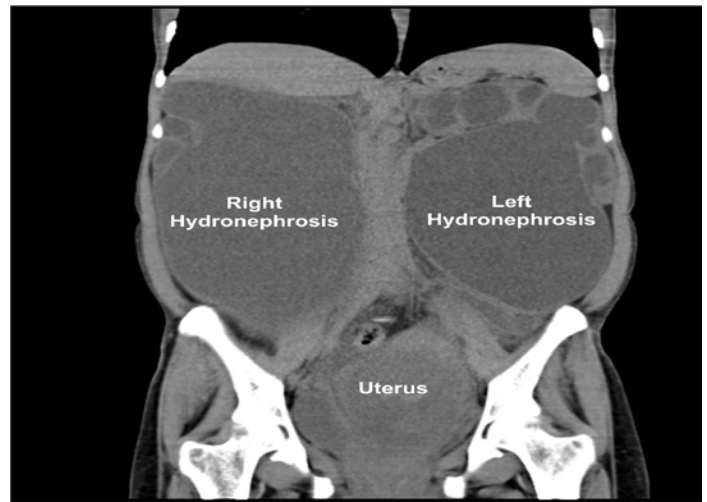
CT scan showing bilateral hydronephrosis
